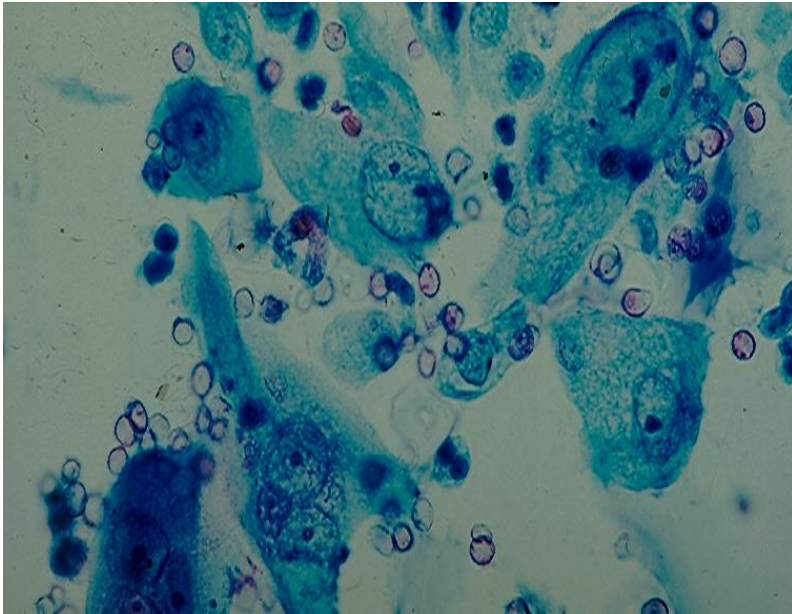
Reactive/repair urothelial cells with conspicuous nucleoli from a patient with bladder lithiasis. (Pap). (Courtesy of Dr. G. B. Schumann, Hartford, CT, USA).
